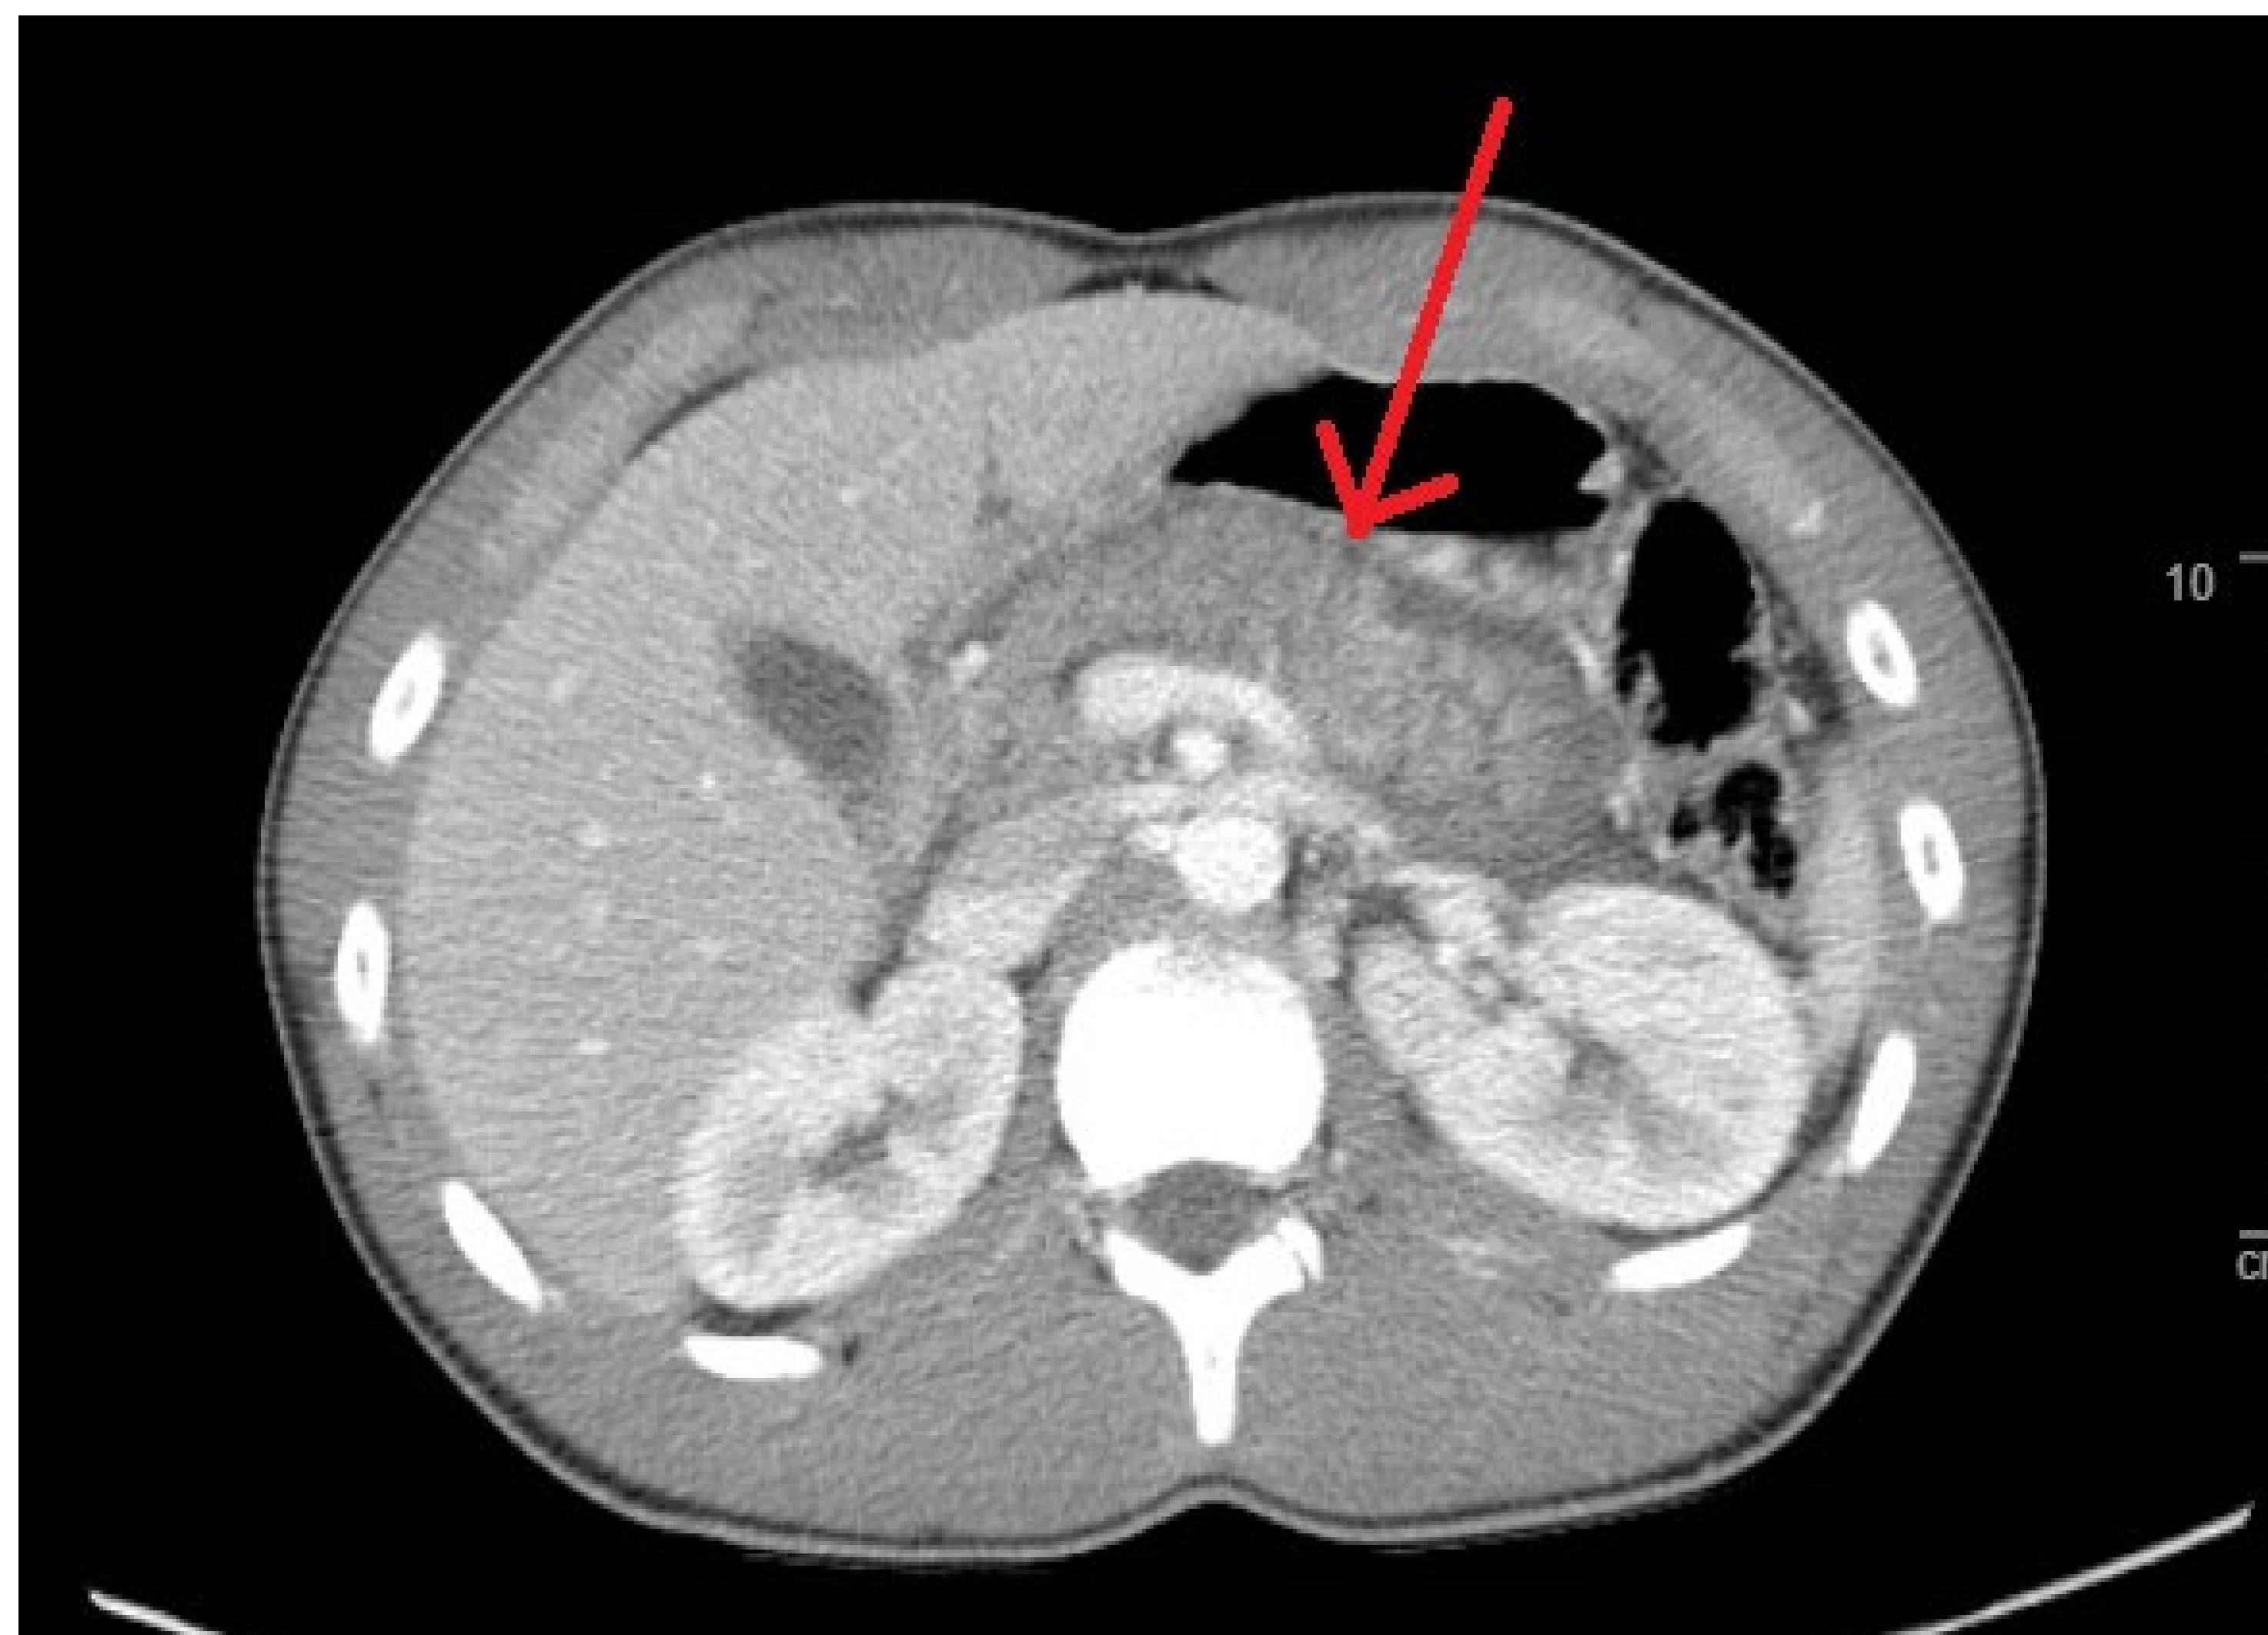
Computed tomography scan with intravenous contrast showing peripancreatic edema and contusion (red arrow).
